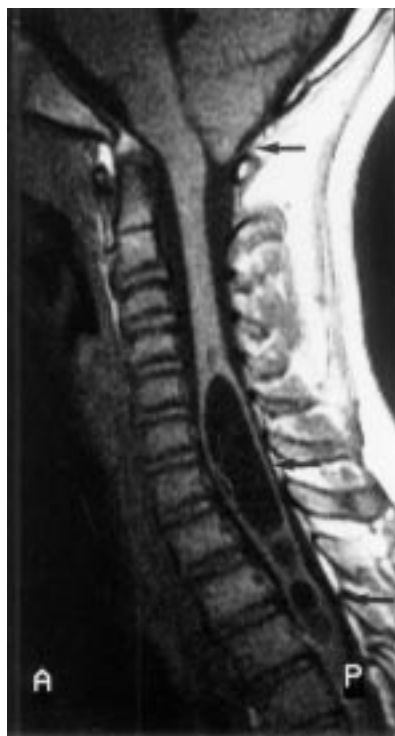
T1 weighted spin echo midsagittal MRI (TR: 404 ms, TE: 15 ms) showing Chiari I malformation with herniated cerebellar tonsils (arrow) and spindle shaped hydrosyringomyelia from C5 to T4 (arrow), with further smaller cavitations to T7 (arrow).
